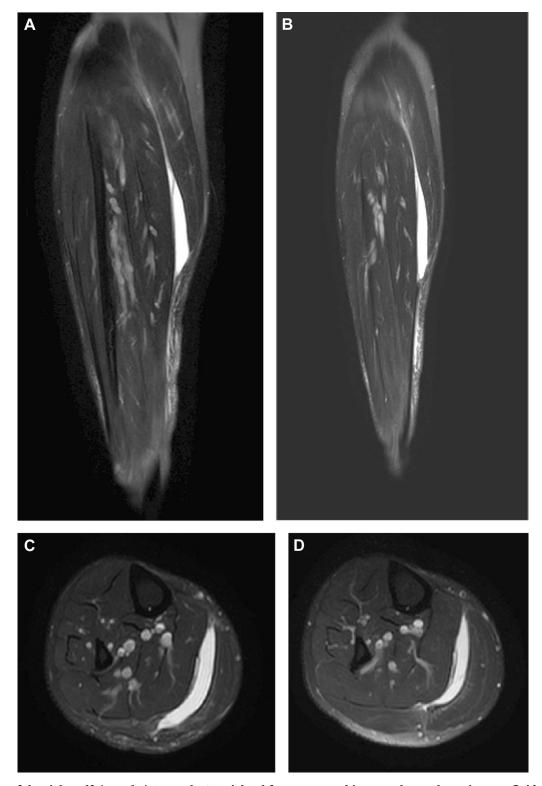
MRI of the right calf. (A and B) Coronal T2-weighted fat-suppressed images show a hyperintense fluid collection between the medial head of the gastrocnemius and soleus. Increased subcutaneous T2 signal is noted along the lower leg. (C and D) Axial T2-weighted fat-suppressed images show a hyperintense fluid collection between the medial head of the gastrocnemius and soleus.
